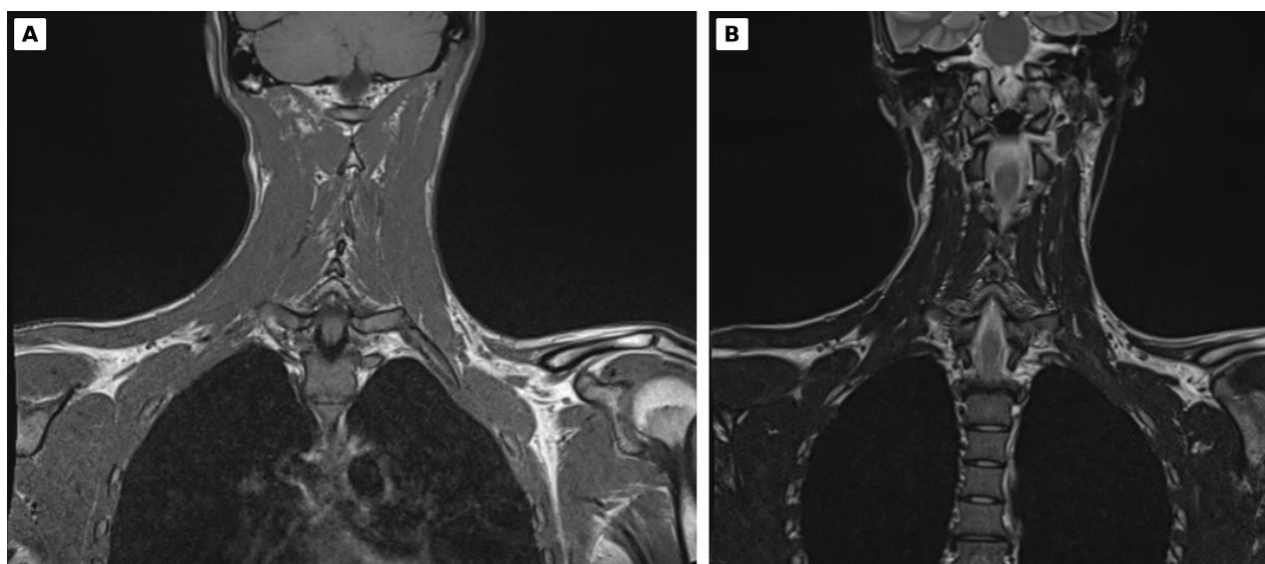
Coronal MRI assessing muscle denervation.
